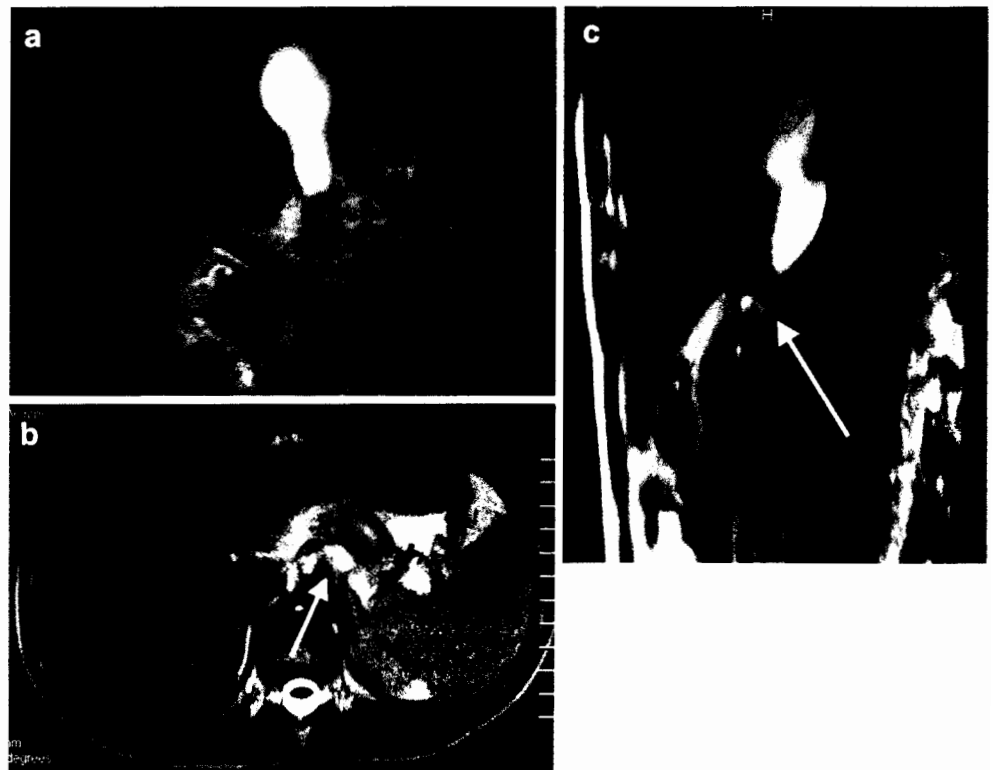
A 9-year-old boy after a fall from a bicycle 24 h previously. Coronal FSE T2-weighted MRI (a) shows a large pseudocyst in the posterior mediastinal space. Axial T2-weighted MRI (b) demonstrates a small fluid collection in the peripancreatic fat (*arrow*). Disruption of a ductal side branch at the pancreatic tail level was suspected. Sagittal view (c) at the pancreatic body demonstrates the continuity of the mediastinal pseudocyst with the pancreatic gland (*arrow*)
